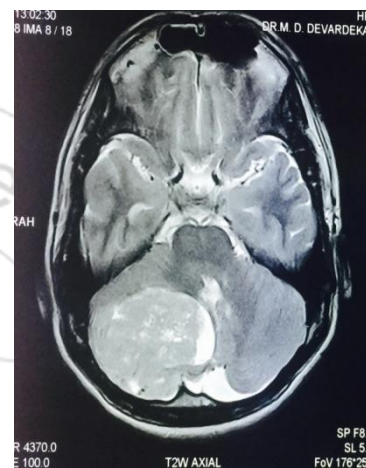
MRI showing right cerebellar hemisphere, intraaxial, hyperintense on T2W & enhancing heterogeneously with contrast.
